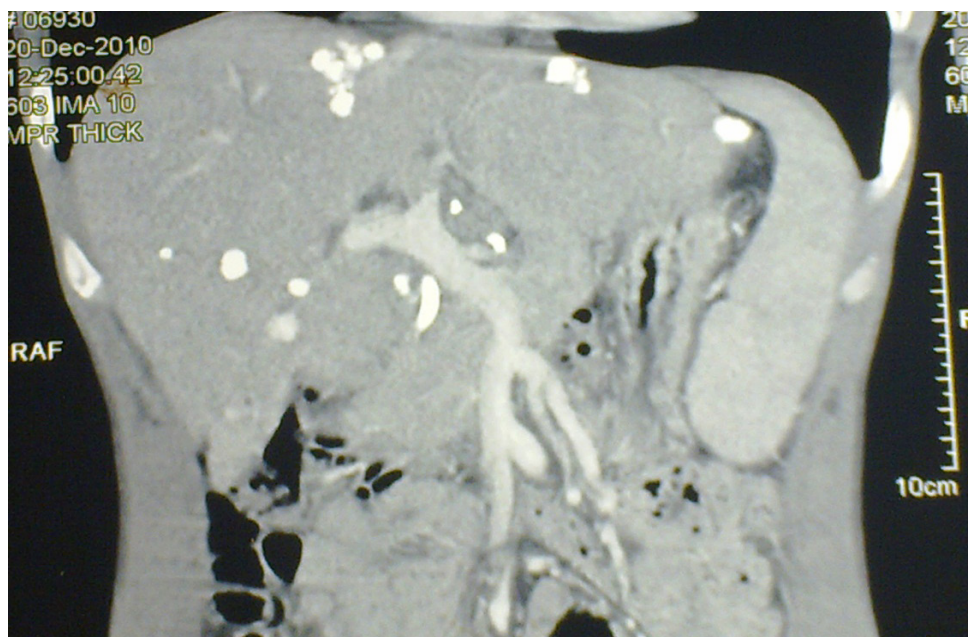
Coronal view of CT liver displayed hepatic calcifications situated at the liver surface
